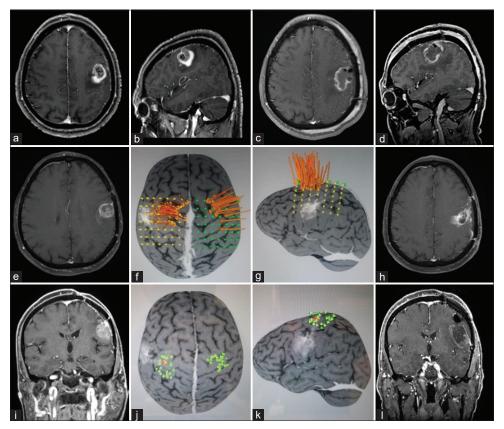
This patient presented a wild-type isocitrate dehydrogenase glioblastoma on the left frontal lobe and underwent three resections. Preoperative postgadolinium T1 magnetic resonance imaging (MRI) axial (a), sagittal (b), early postoperative MRI axial (c), sagittal (d), second resection preoperative postgadolinium T1 MRI axial (e), preoperative motor cortex mapping using navigated transcranial magnetic stimulation (TMS): long arrows point location of M1 activation using nTMS (f and g), late postoperative axial (h), third resection preoperative postgadolinium T1 MRI coronal (i), preoperative motor cortex mapping using navigated TMS (j and k), early postoperative coronal (l).
